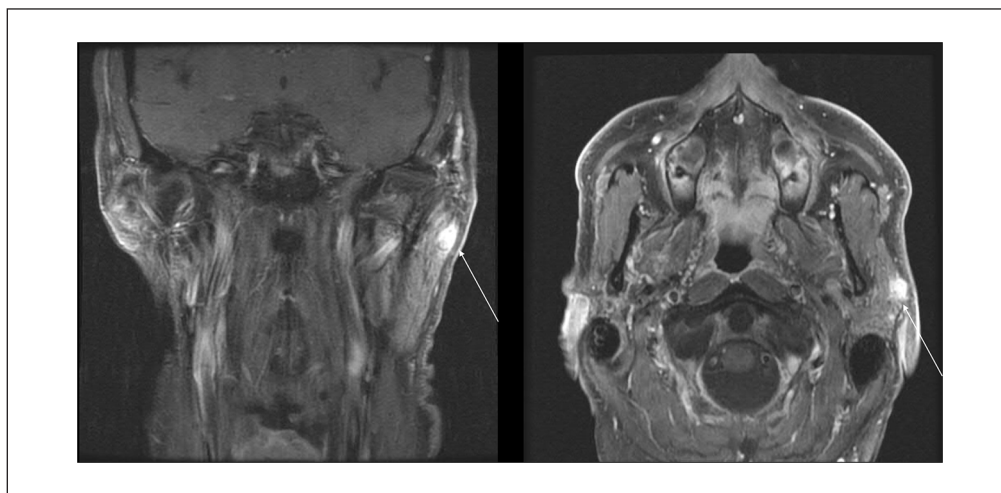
T1, fat suppressed, gadolinium-enhanced coronal and axial MRI images of the left-sided secretory carcinoma, diagnosed in 2015. Arrows indicate the tumor, which is located in the superficial lobe of the parotid gland and appears as an enhancing mixed signal. There is mild exophytic extension into adjacent subcutaneous tissues.
